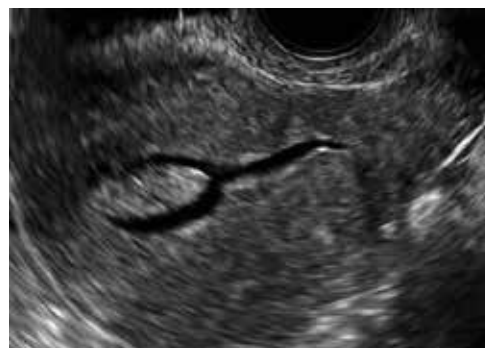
Sagittal view of uterus with endometrial cavity distended by saline (sonohysterogram or saline-infusion sonogram), demonstrating fundal endometrial polyp. Image courtesy of Andrew Kaunitz.
